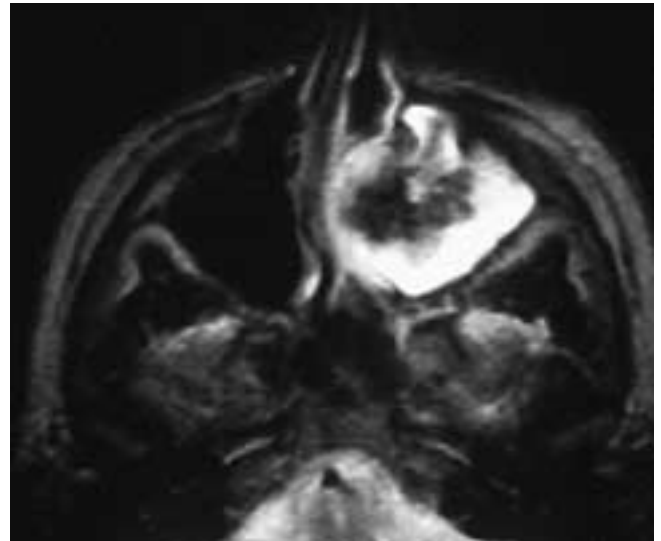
Axial T2-weighted MR image shows inflammatory disease with a high signal intensity in the left maxillary sinus. Centrally within the sinus is a region of both low signal intensity and signal void. This was an aspergilloma. This patient had aspergillosis.
